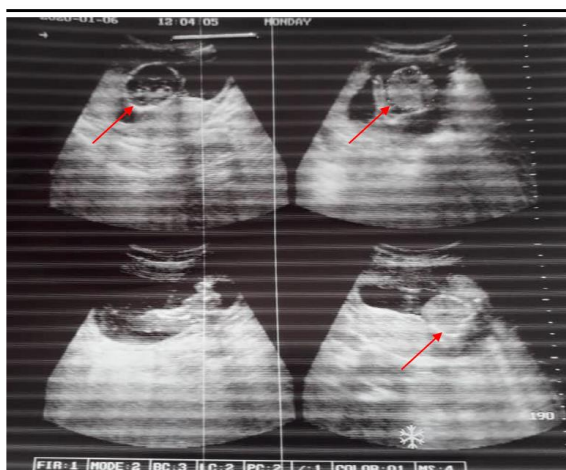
Pelvic ultrasound showing an intrauterine viable fetus
